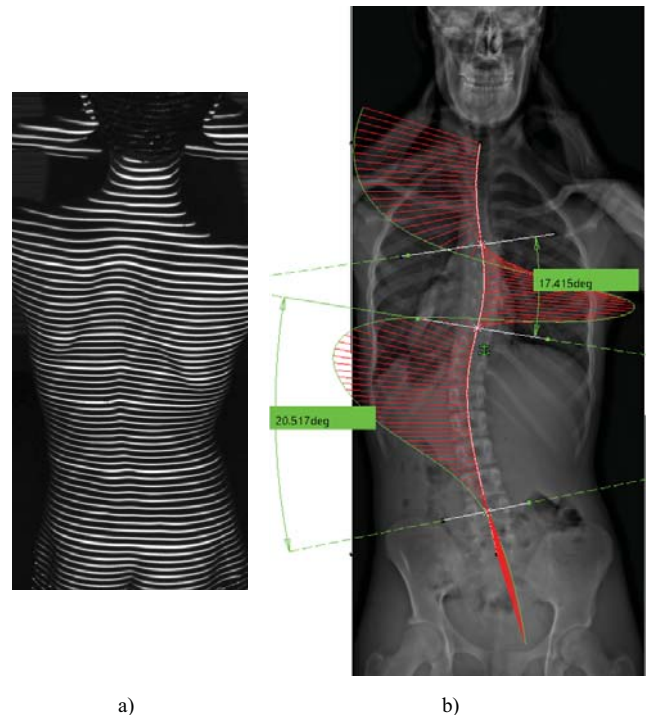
Evaluating scoliosis: a) visual inspection - optical diagnosis, b) traditional radiographic assessment through measuring primary and secondary Cobb angles on X-ray images.
